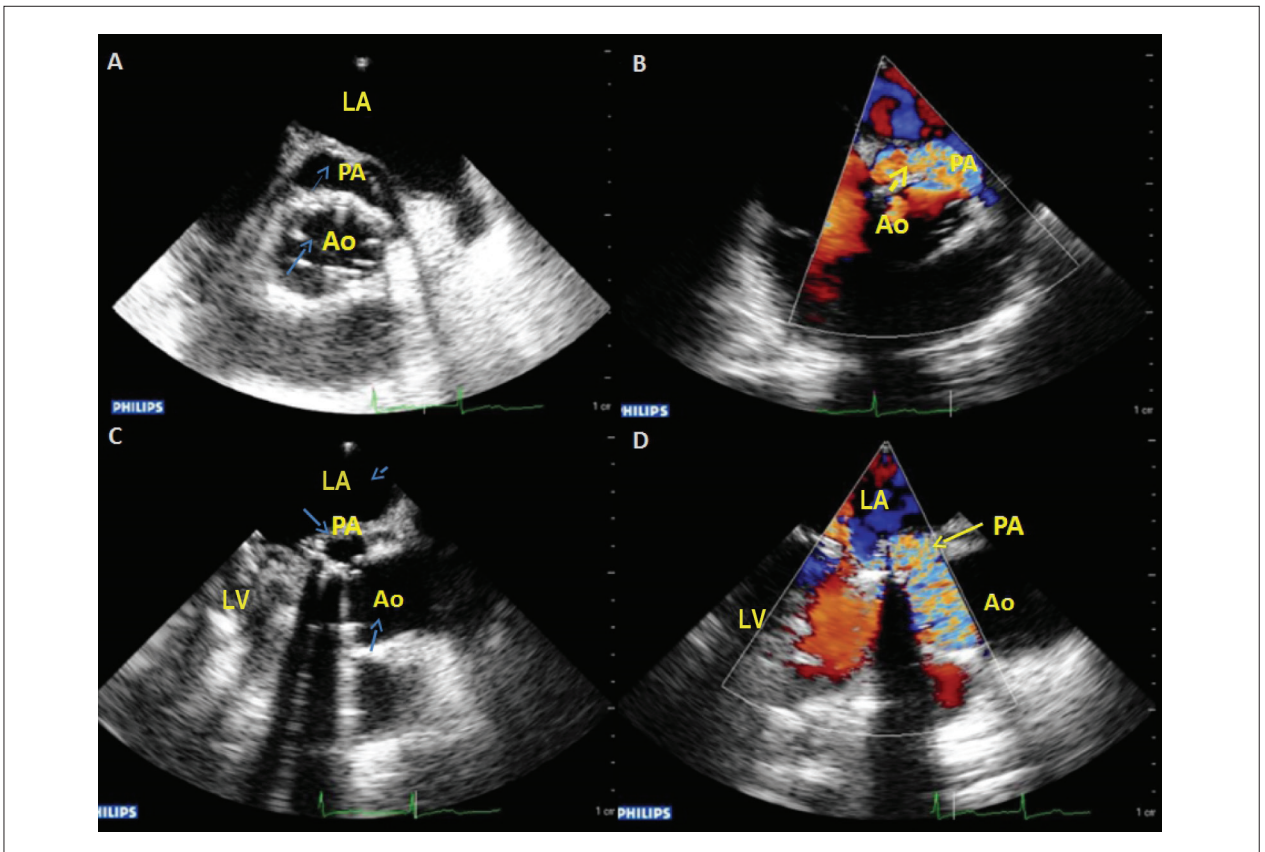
Echocardiogram images A, B, C and D. A and B: aorta longitudinal cross-section of the pseudoaneurysm (PA). C and D: Transesophageal echocardiogram at 130 degrees showing PA communication hole with the ascending aorta. PA: pseudoaneurysm; Ao: aortic valve; LA: left atrium.
